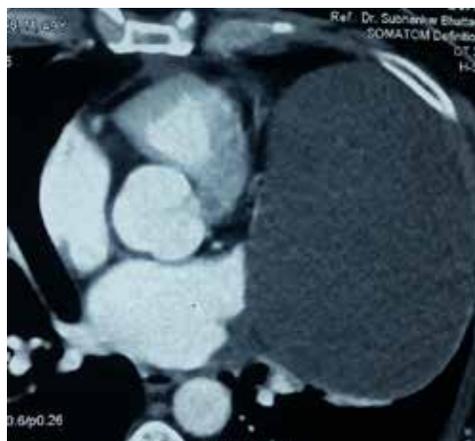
CT showing a giant pericardial cyst.
